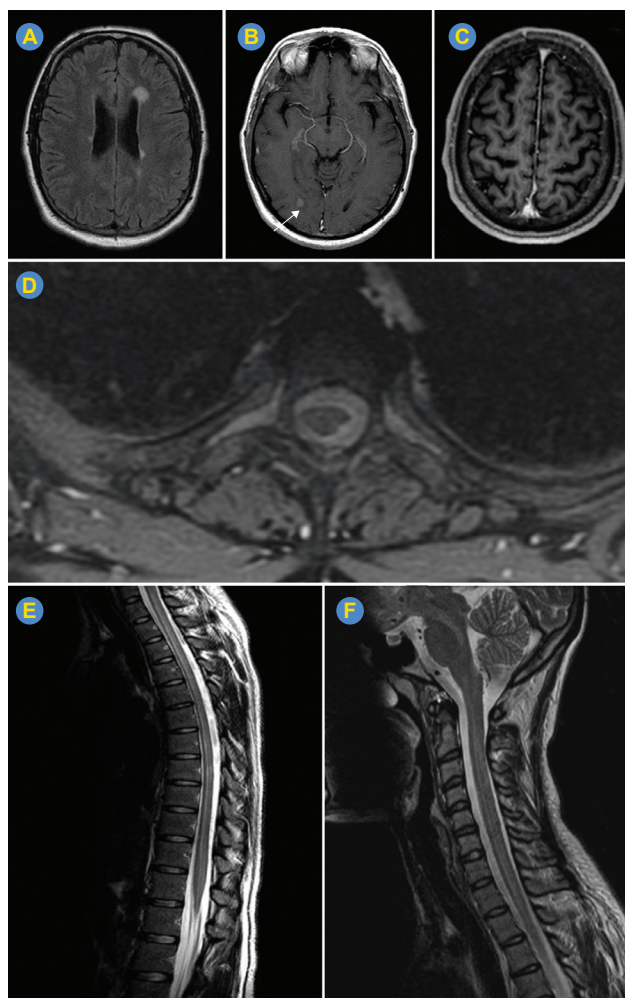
MRI at disease onset. Oval, periventricular white matter lesions in FLAIR-WI, and one gadolinium-enhancing lesion (arrow) (A, B, Patient 15). Sagittal T1-WI after gadolinium administration displays mild pachymeningitis at left parasagittal parietal dura (C, Patient 14). Patient 7 features circumferential thickening of the dura (hypertrophic pachymeningitis), from C6-D12, with marked gadolinium-enhancement as shown in axial T1-WI at lower dorsal level (D). Extensive hyperintensity of spinal cord on T2-WI between T2 and conus medullaris (LETM) (E, F, Patient 13).
